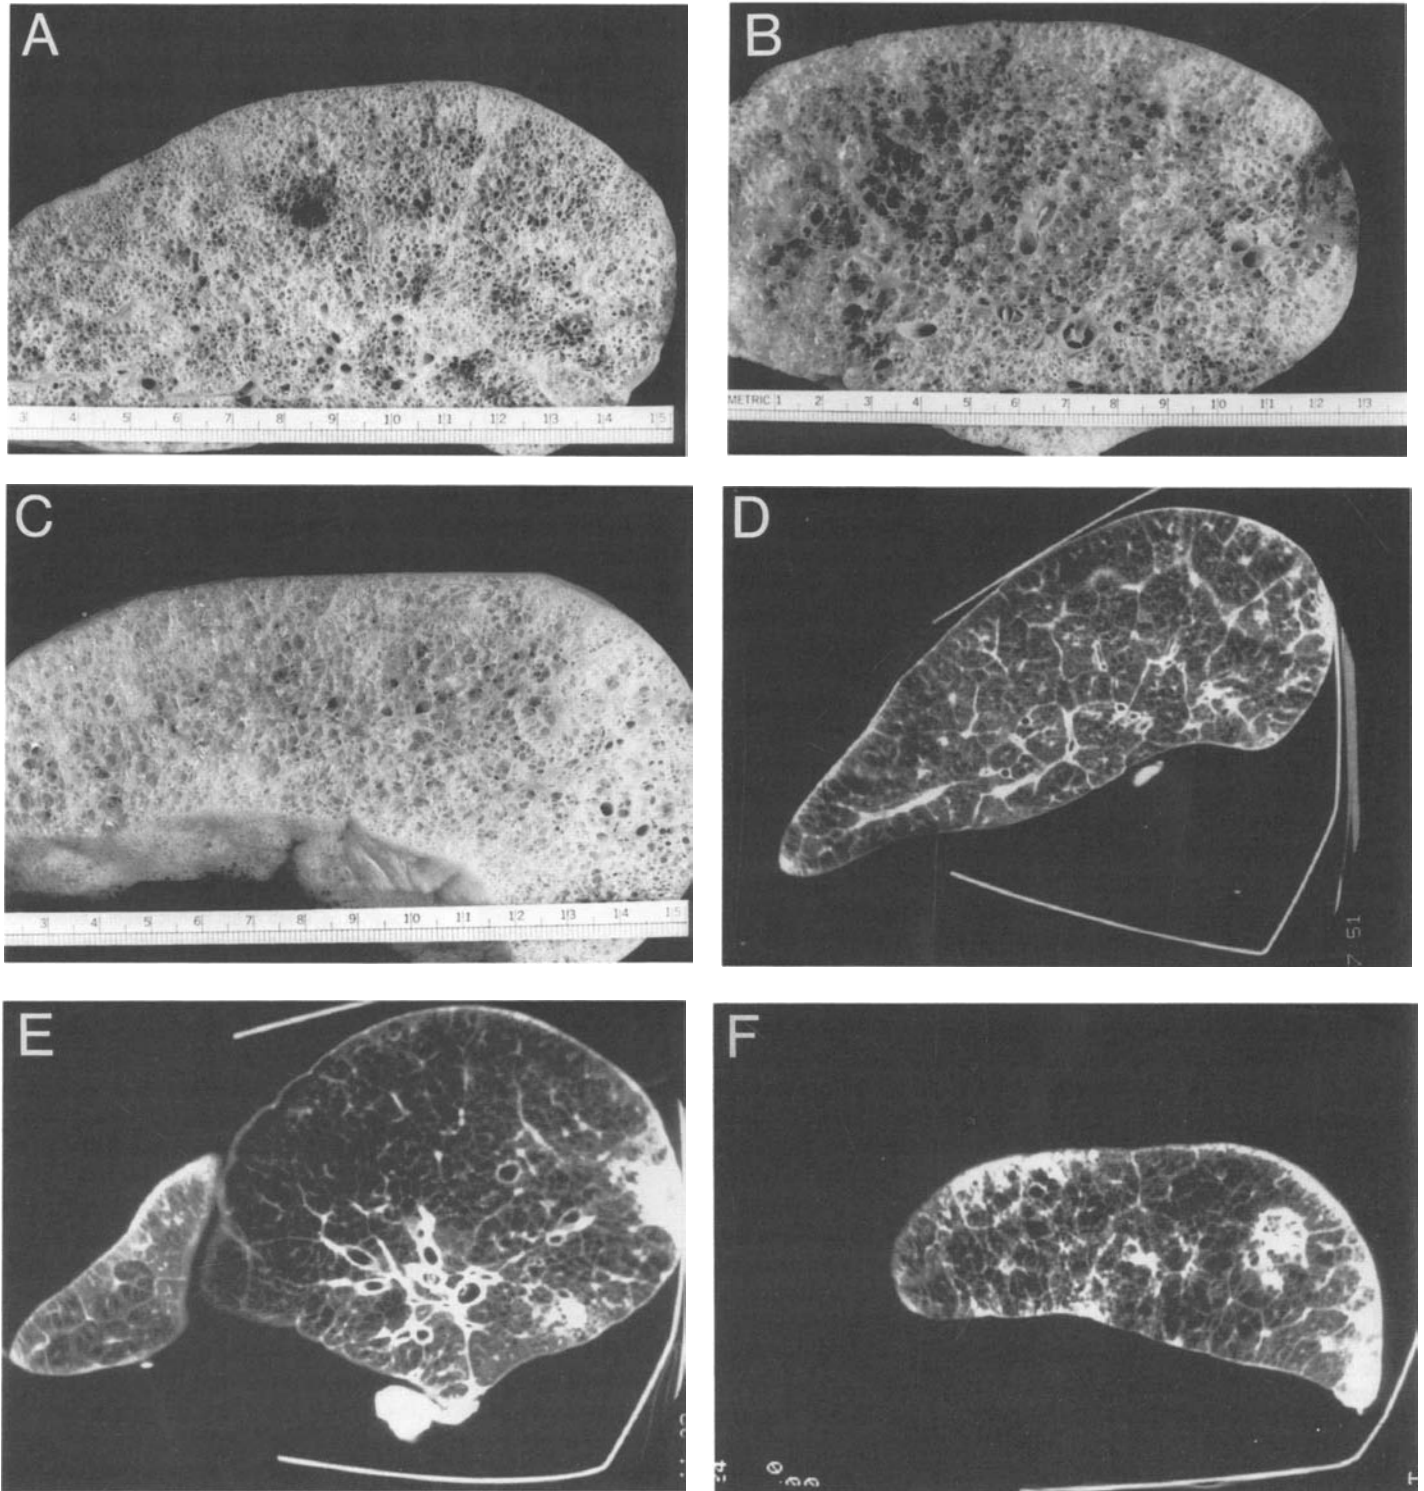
Gross pathologic findings and HRCT studies from Patient 1. Transverse sections from the upper (A, D), middle (B, E), and lower (C, F) zone of the inflated, dried left lung are shown next to the HRCT scan at approximately the same level. Internal scale is in centimeters.
